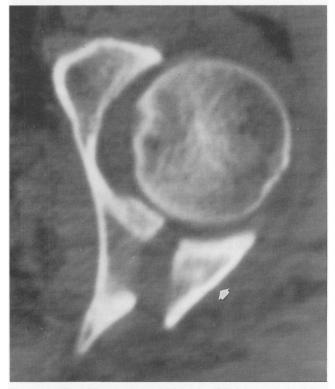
The CT scan through the joint demonstrates the large posterior wall fragment (white arrow).
